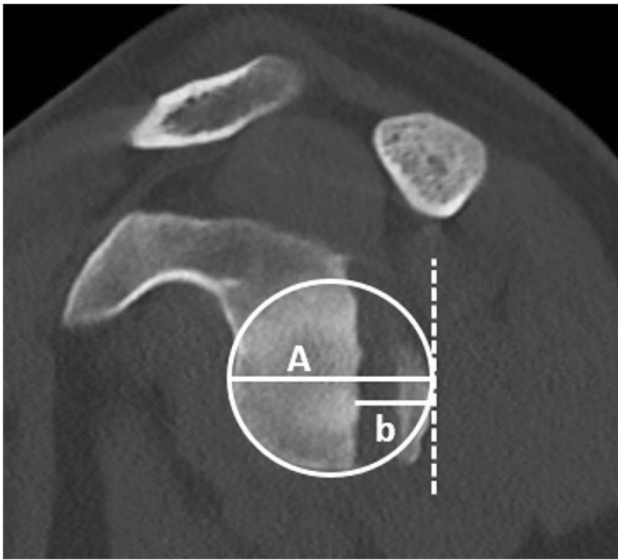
Sagittal CT image demonstrates measuring the extent of glenoid bone loss in the setting of a reverse bony Bankart using the best-fit-circle method, which superimposes a circle over the glenoid articular surface. The defect size (b) divided by the glenoid diameter (A) equals the percentage of glenoid bone loss
